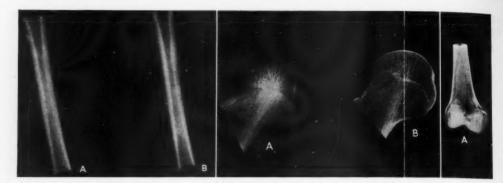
A (left). Roentgenogram of the proximal two-thirds of a normal macerated femur shaft.
